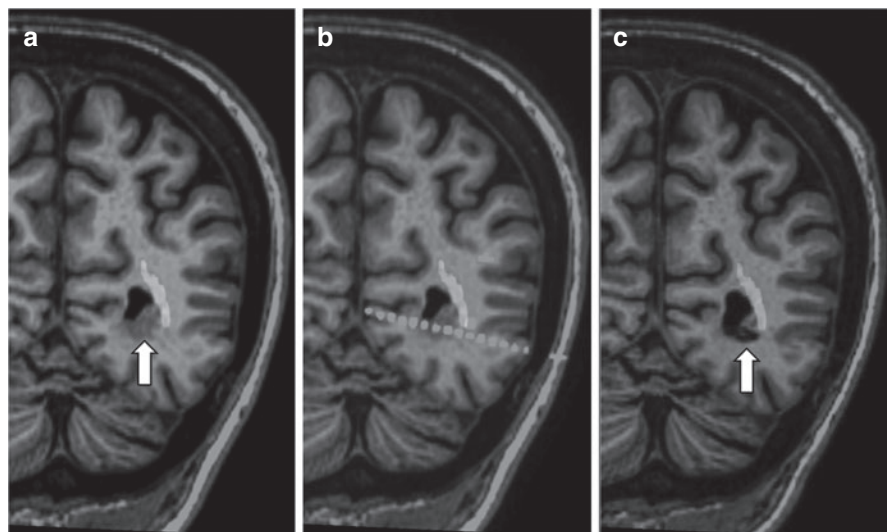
T1-weighted MR scan of a periventricular nodular heterotopy (arrow) of the left occipital horn, displaying the optic radiation obtained from DTI-based fiber-tracking (a). In (b) the SEEG electrode placed with robotic assistance within the nodule and brushing the inferior border of the optic radiation is shown. The nodule has been coagulated (arrow) sparing the optic radiation (c)
